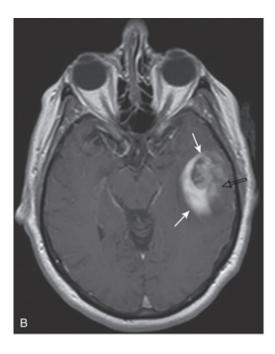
Axial T1 post-gadolinium MRI - mass in left temporal lobe (white arrows), with necrosis (black arrow), and leakage of contrast into the brain parenchyma [6]
